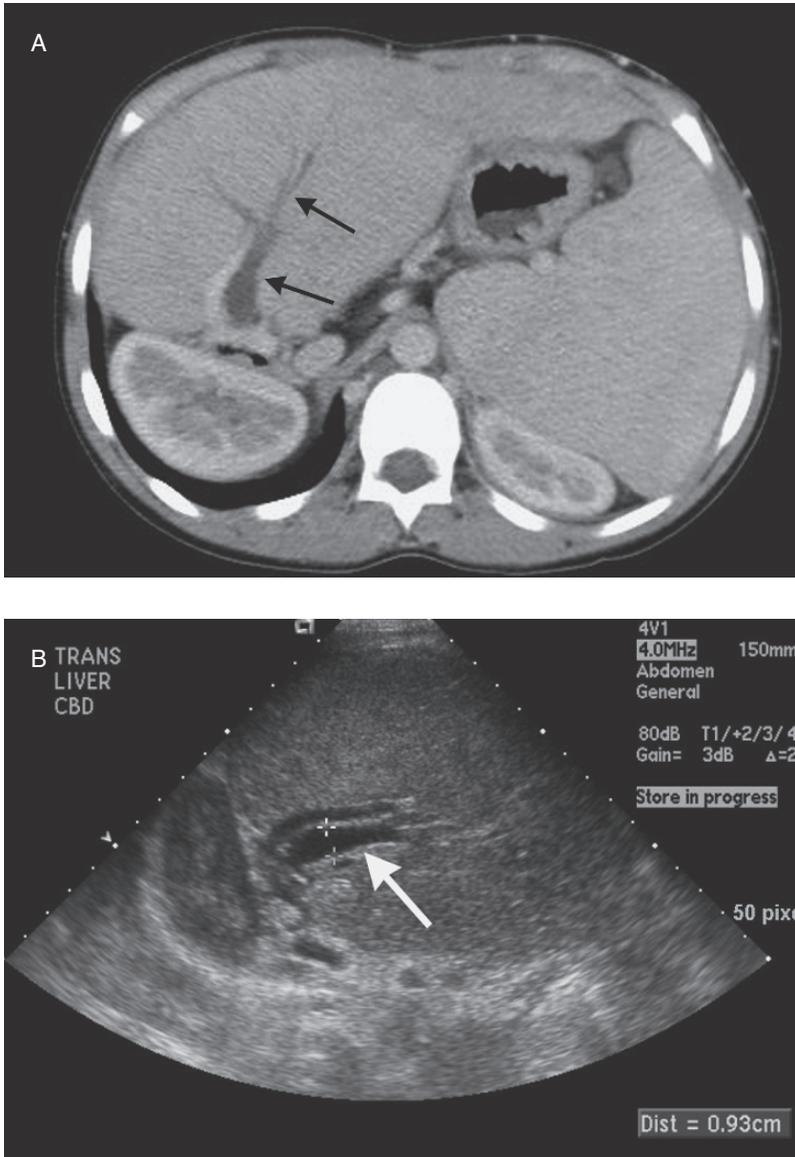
Biliary stricture. This patient has had a partial hepatic resection for hepatoblastoma. He had a choledochojejunostomy, but presents years later with jaundice. (A) Intrahepatic bile duct enlargement (arrows), confirmed on (B) ultrasound (arrow). (C) Small needle access (arrows) into a peripheral bile duct (arrowhead). Subsequently, a drain was placed. (D) Cholangiogram through the drain, showing obstruction (arrow) at the choledochojejunostomy.
